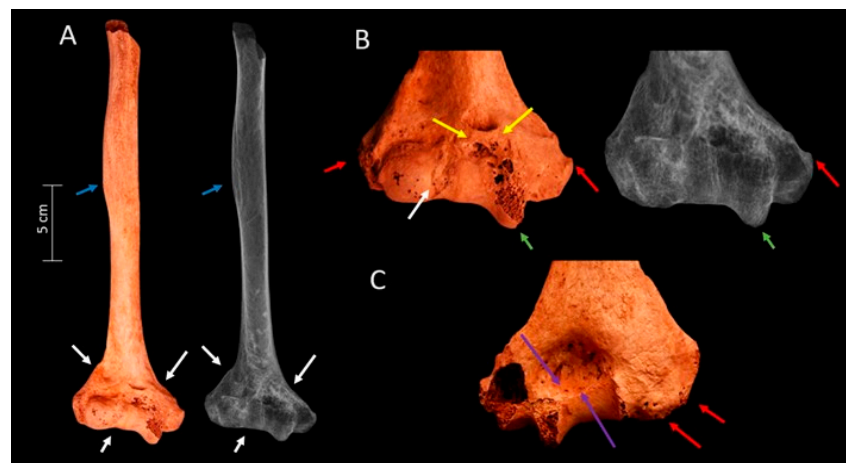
Humerus-009 from FU-221 and SU-2369. Anterior view of the humerus with the associated radiograph (A). Magnification of the anterior view of the distal humerus with the associated radiograph (B). Magnification of the posterior view of the distal humerus (C). Blue arrows indicate a prominent deltoid muscle insertion. White arrows show remodeling of the fracture at the distal epiphysis. Green arrows indicate post-traumatic arthritis in the trochlea and changes in its size. Yellow arrows highlight osteophytes secondary to post-traumatic arthritis. Red arrows show osteophytes and post-traumatic arthritis at the capitulum, medial, and lateral condyles. Purple arrows indicate post-traumatic arthritis in the olecranon fossa.
